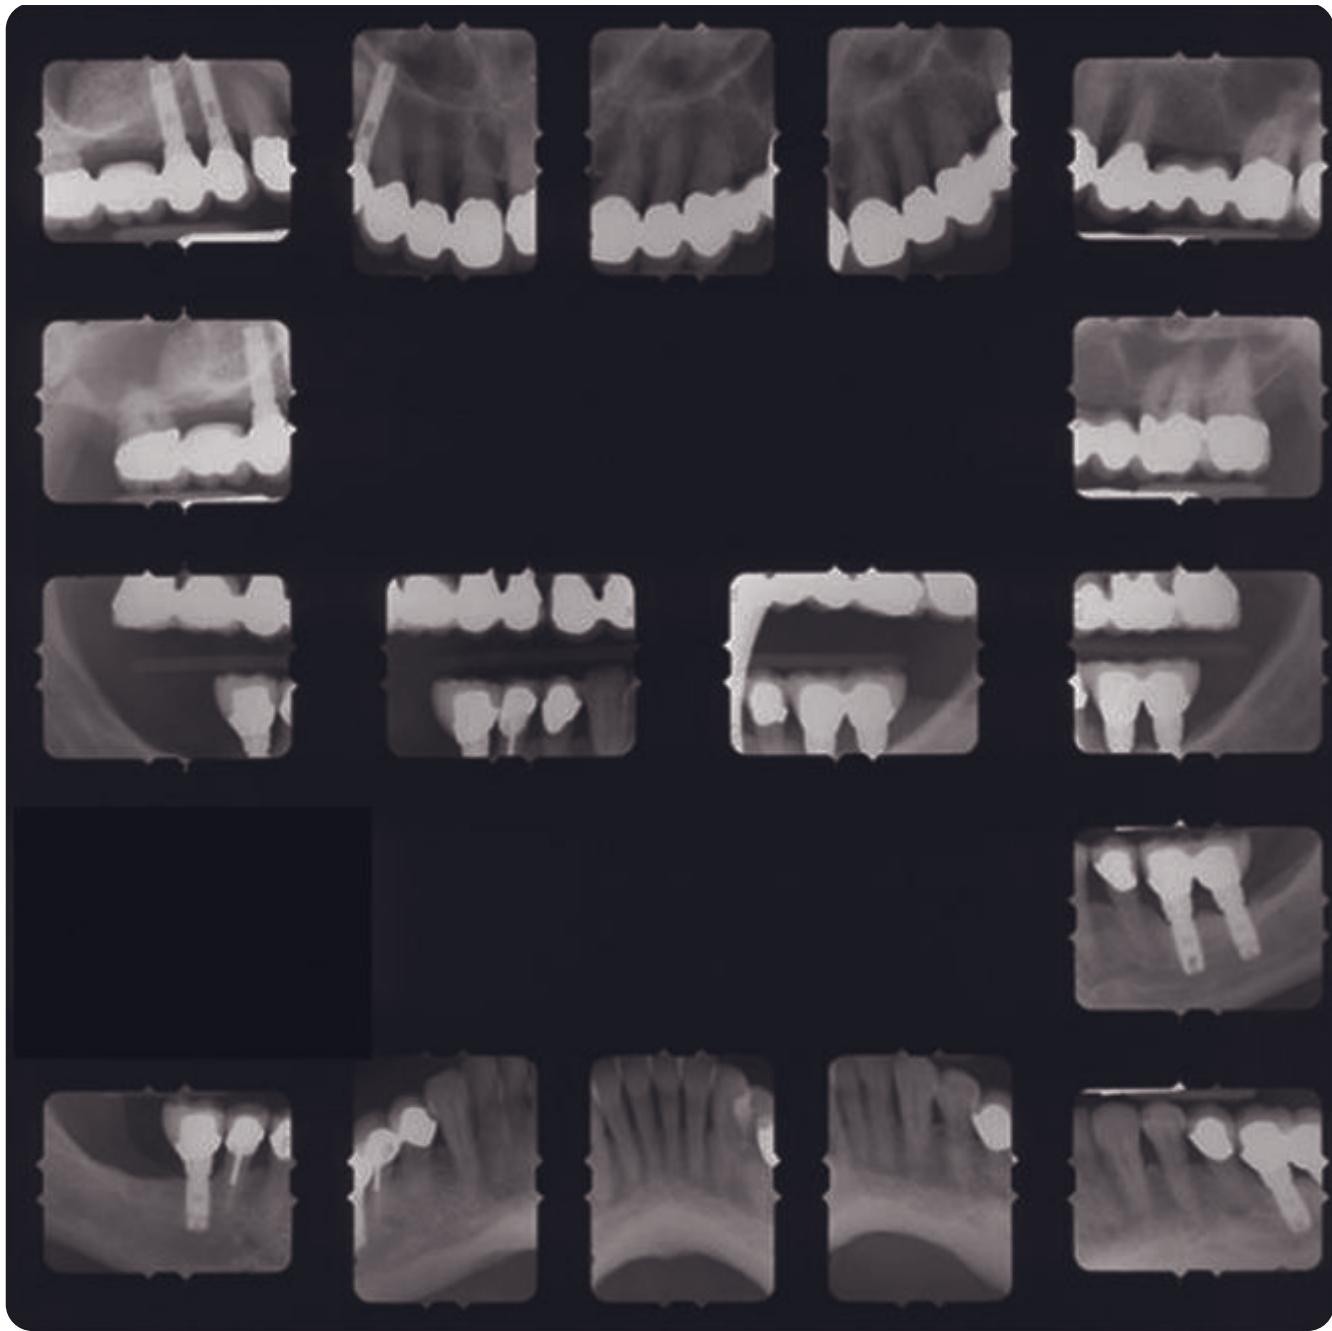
Seven-year follow-up radiographs. Note bone levels have stayed consistent, as have mobilities.
